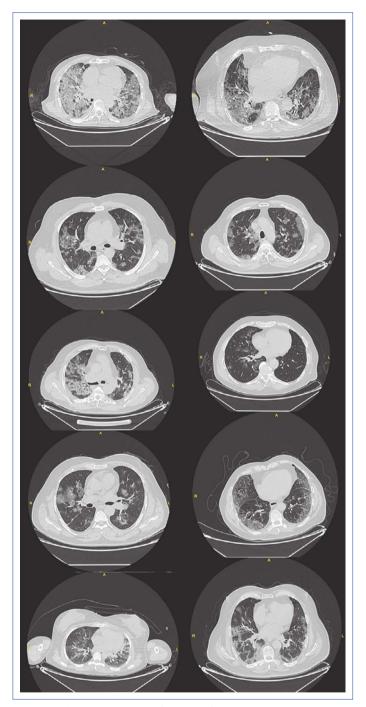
Thorax CT images of patients from 1 to 12. CT: Computed tomography.
